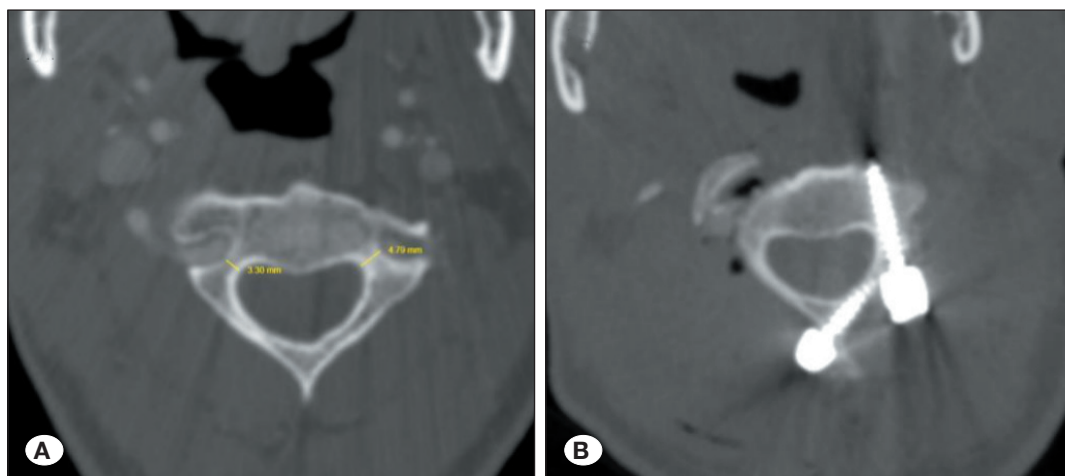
Hybrid C1–C2 construct in os odontoideum with narrow C2 pedicle. A 50-year-old male underwent C1–C2 fusion. A) Preoperative computed tomography angiography (CTA) demonstrating narrow right C2 pedicle (3.30 mm) compared with the left (4.79 mm). B) Postoperative axial CT showing hybrid construct with the right C2 laminar screw and left C2 pedicle screw.
